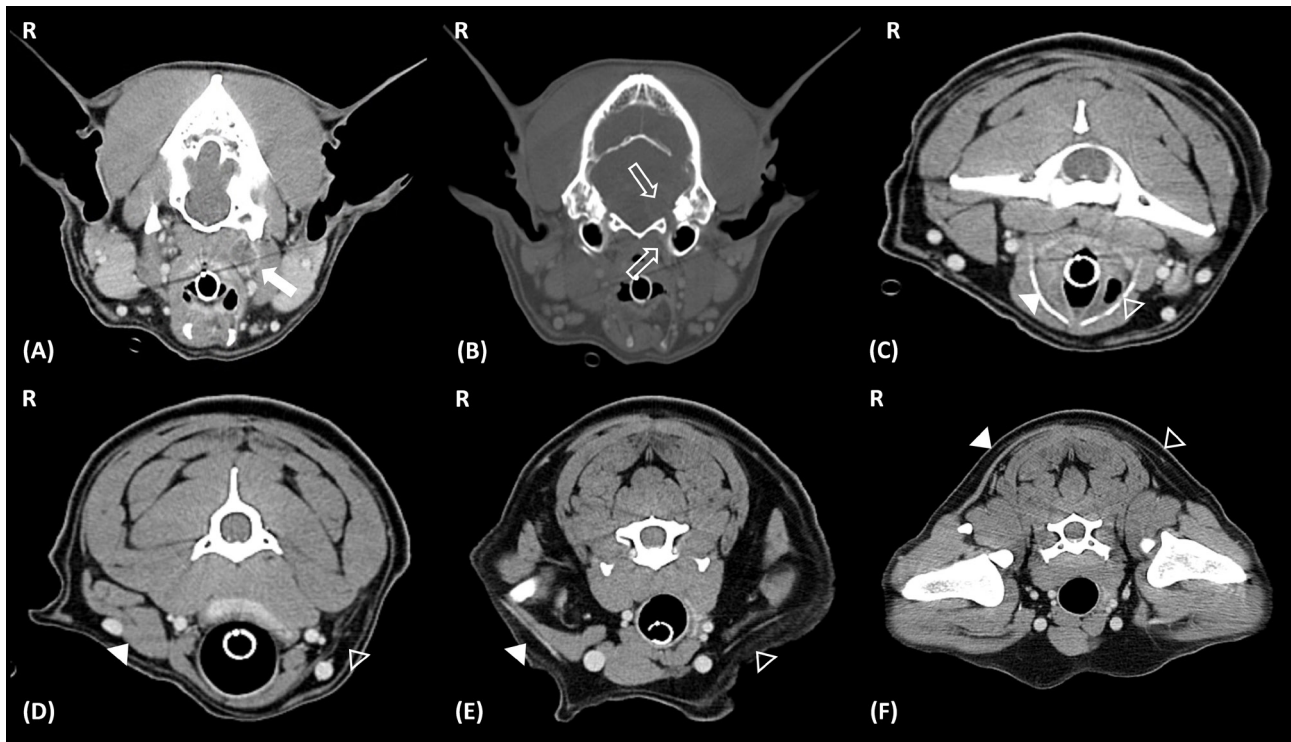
Computed tomography (CT) images of the skull and muscle atrophy. Left side corresponds to the right side of the patient. A- Transverse post-contrast CT image (soft tissue window). The extracranial lesion was well-defined, relatively oval-shaped, and slightly enhanced (white arrow). A rim-enhancing pattern (up to 128 HU) was also observed. B- Transverse post-contrast CT image (bone window). It demonstrates smooth widening of the left jugular foramen and marked osteolysis of the tympanic part of the left temporal bone (open white arrows) compared to the contralateral side. C- Vocal fold (Thyroarytenoid muscle, Cricothyroid muscle). D- Sternocleidomastoid muscle. E- Cleidocleidomastoid muscle (mastoid part). F- Trapezius muscle. Severe unilateral muscle atrophy is evident on the left side, ipsilateral to the location of the mass. [Normal muscles: white arrowheads, atrophy of muscles: open white arrowheads].
